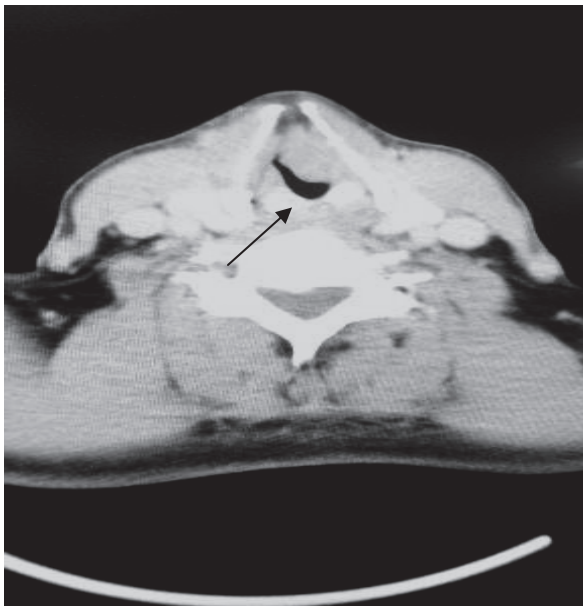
The CT image of the mass that blocks the larynx passage.
